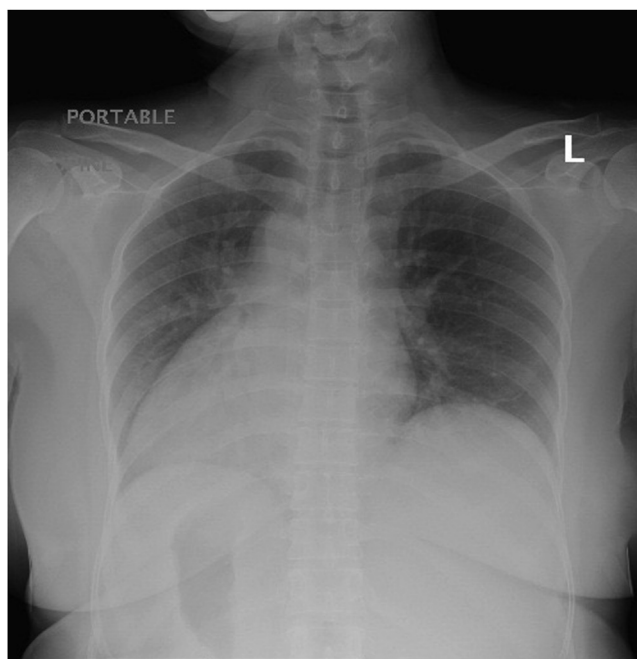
Chest X-ray revealed dextrocardia.
